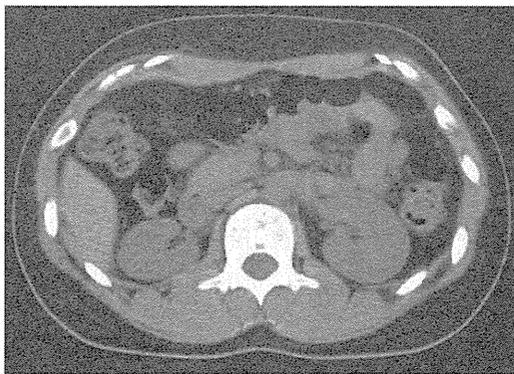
Computed tomography showing right renal hypoplasia.
